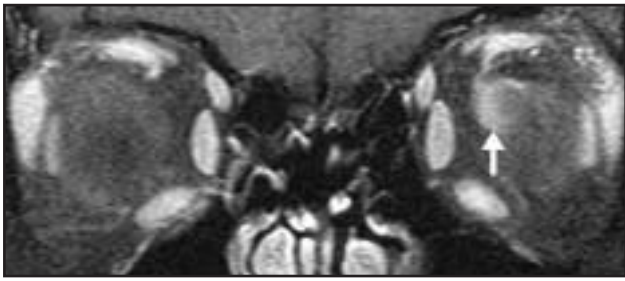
Intradural optic nerve sheath meningioma. A T1-weighted, contrast-enhanced coronal MRI shows growth of the meningioma in a subdural pattern within the left nerve sheath partially surrounding the optic nerve within (arrow).
